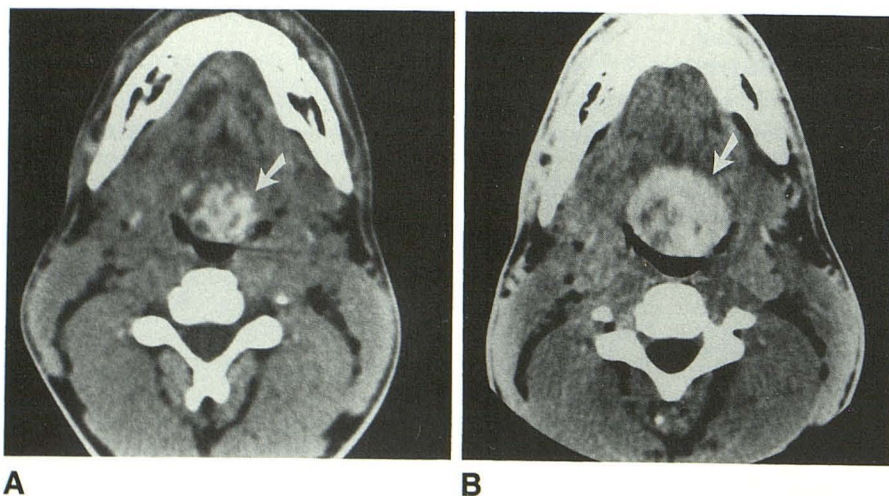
A and B, Axial unenhanced (A) and enhanced (B) CT scans of upper part of neck show high concentration of iodine in thyroid gland (arrows) at base of tongue, compromising the oropharynx.
